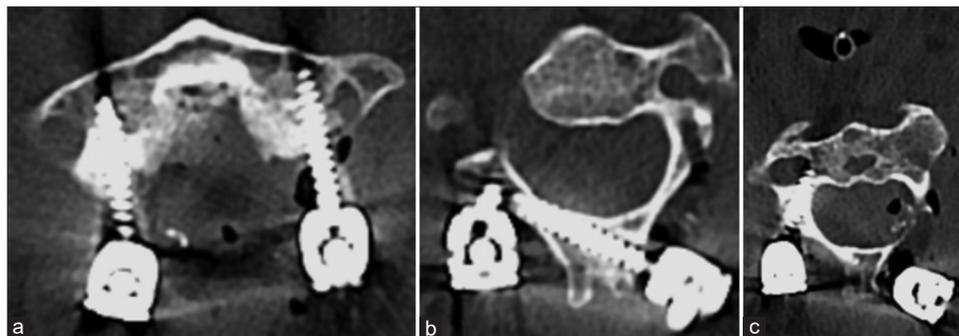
(a) Postoperative CT scan axial cut at the level of C1 showing bilateral lateral mass screws and (b) axial CT cuts at the level of C2 showing right laminar screw. Tract made for pedicle screw insertion on the left side is also appreciated (responsible for fistula formation). (c) Right pedicle screw at C2.
